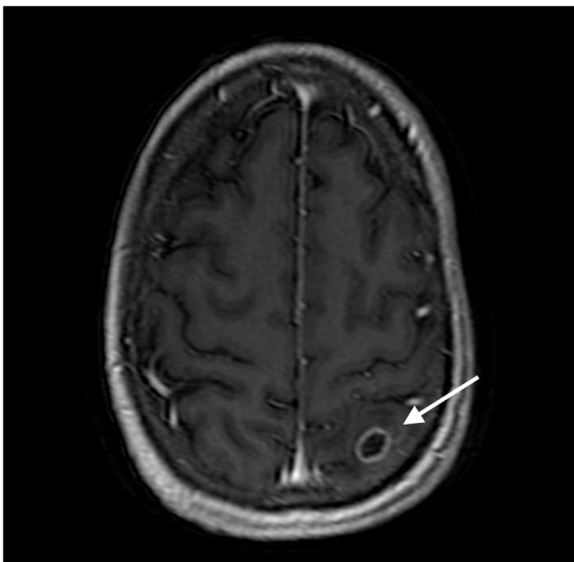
Axial view of brain MRI showing rim enhancing lesion in left parietal lobe.
